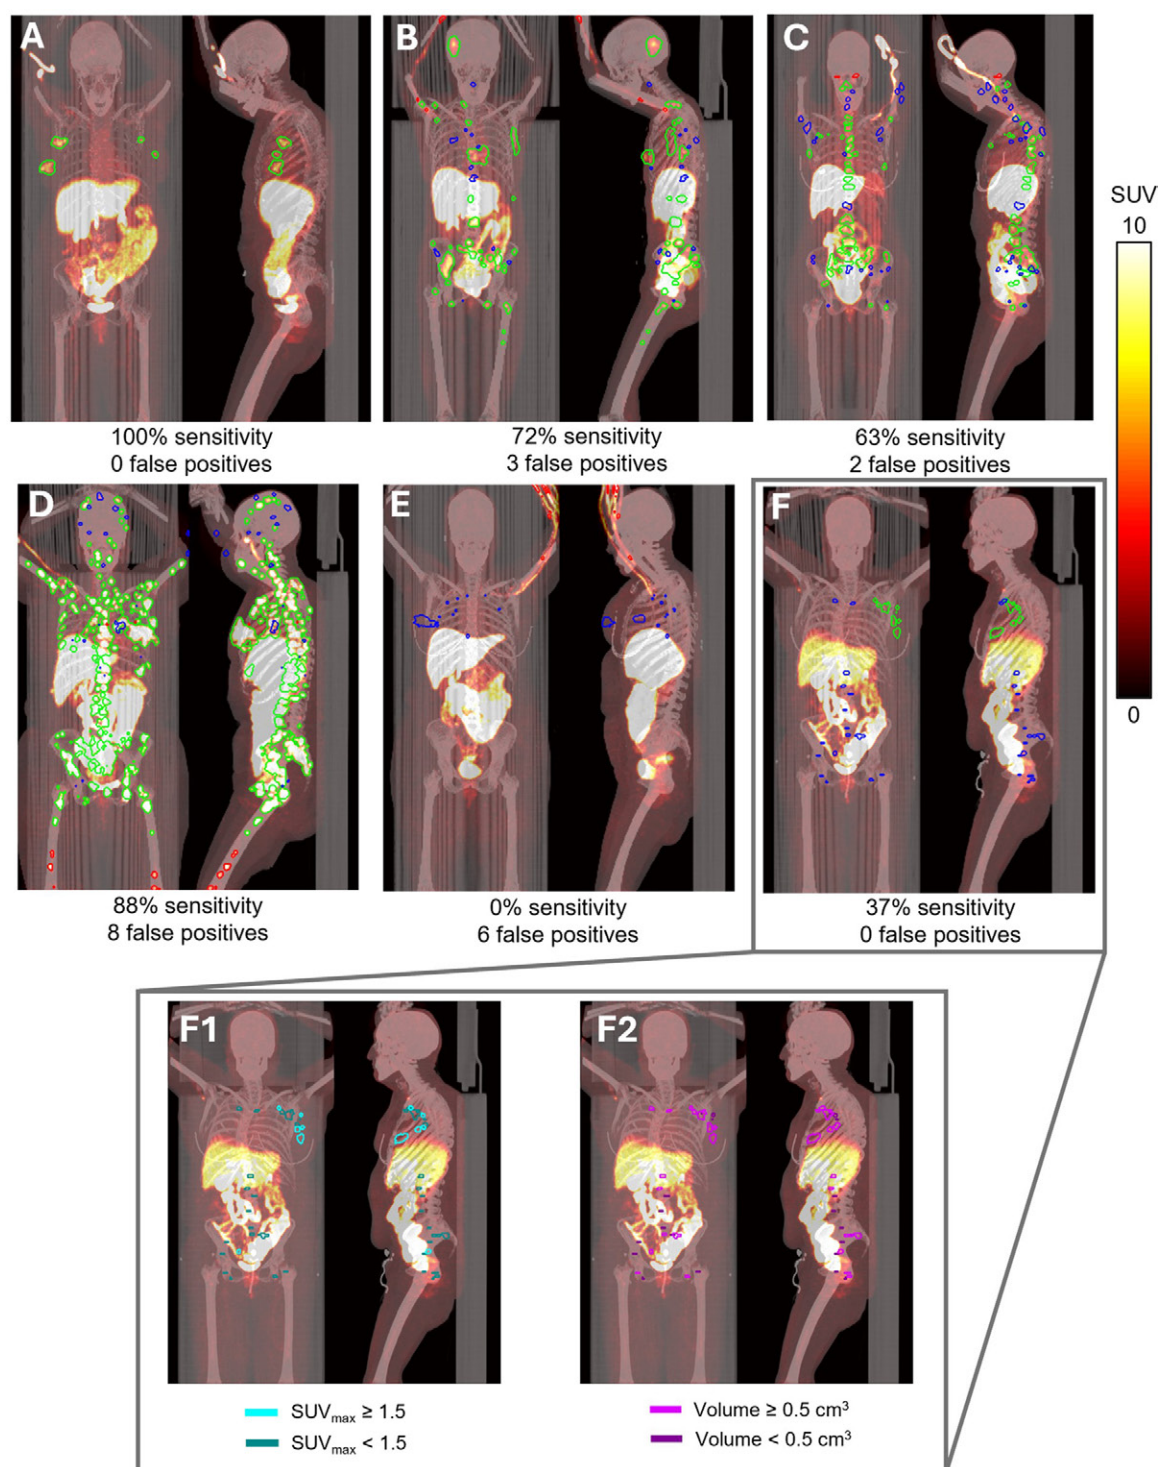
Example scans in women with breast cancer of automated lesion identification from fluorine 18 (^{18}F)-fluoroestradiol (FES) PET/CT highlighting true positives (green), false positives (red), and false negatives (blue). (A) All four lesions labeled in the reference standard annotation were detected by the model (100% sensitivity). (B) Thirty-three of the 46 lesions were detected by the model (72% sensitivity), whereas 13 lesions were not (false negatives). Additionally, three regions were labeled by the model that were not labeled by the expert reader (false positives). These false positives were located in the peripheral vein where the tracer was injected. (C) The model detected 46 of 72 lesions (63% sensitivity) but found two additional regions (false positives). (D) One case with relatively high sensitivity (finding 167 of 189 lesions, 88%) yet with eight false positives. Most missed lesions from this case were in the head and upper extremities. The false positives were in the right and left femur and could indicate lesions missed by the human reader. (E) The case shows numerous false positives in the peripheral vein where the tracer was injected. At the same time, the model failed to detect all lesions in the chest. (F) The model only detected 10 of 29 total lesions (34% sensitivity) labeled in the reference standard. The same participant is shown in panel F, highlighting lesions that had (F1) low tracer uptake (maximum standardized uptake value $[SUV_{max}] < 1.5$) and (F2) small lesions (volume $< 0.5 \text{ cm}^3$).
